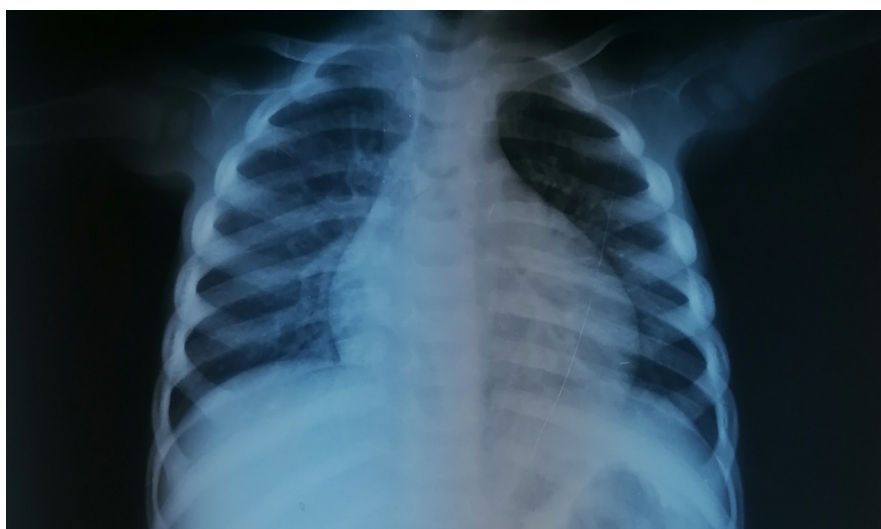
Frontal chest X-ray of 15 months old child.
